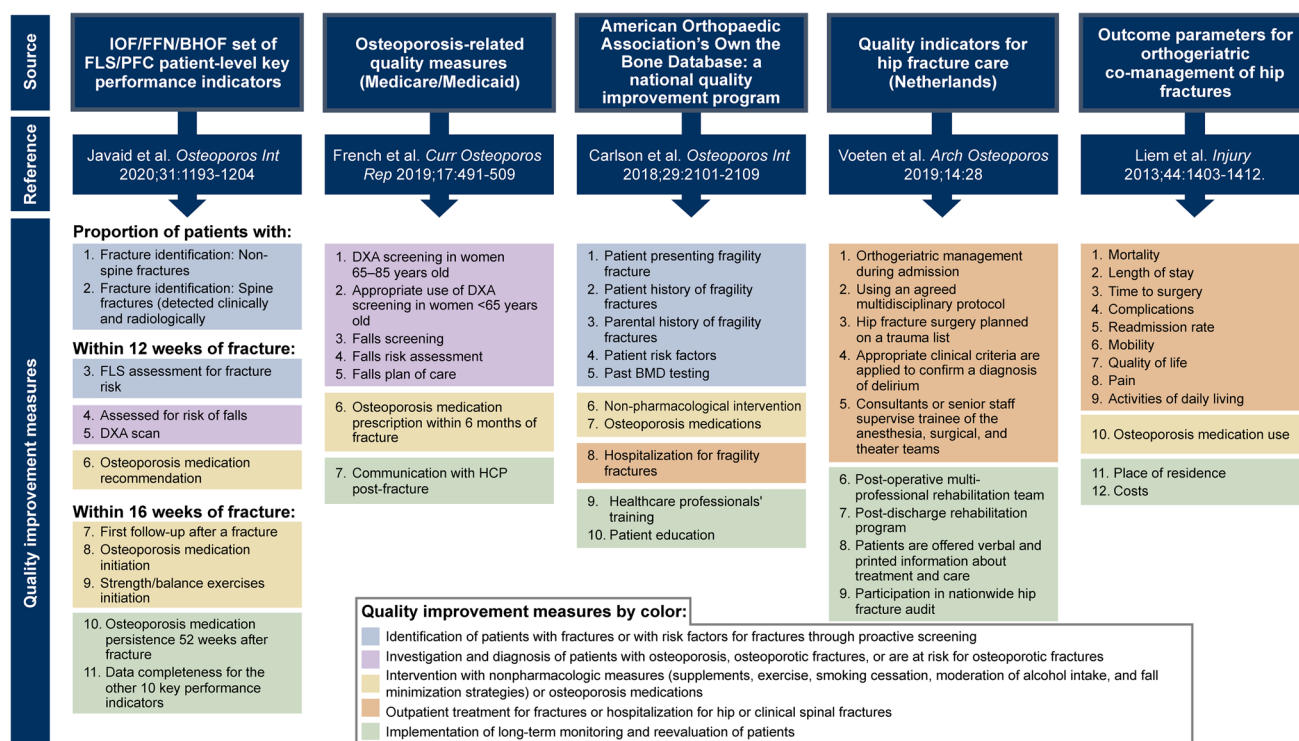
Signals of harmonized quality improvement measures. *BMD*, bone mineral density; *DXA*, dual-energy X-ray absorptiometry; *FFN*, Fragile Fracture Network; *HCP*, healthcare professional; *FLS*, fracture liaison service; *IOF*, International Osteoporosis Foundation; *BHOF*, National Osteoporosis Foundation; *PFC*, post-fracture care
